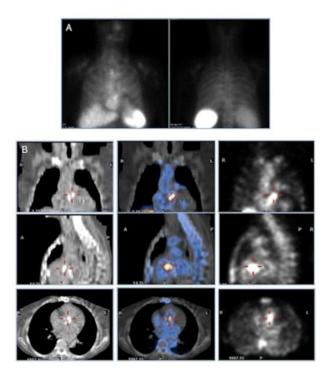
^{99m}Tc-HMPAO-WBC scintigraphy demonstrating the value of SPECT/CT for precisely localizing the site of infection. (A) Planar anterior and posterior views (anterior in left panel, posterior in right panel), where focal uptake of radiolabeled WBCs mimic sternal osteomyelitis. (B) Coronal, sagittal, and transaxial CT sections in left panels, fused SPECT/CT sections in middle panels and SPECT sections in right panels. The tomographic images correctly localize uptake of ^{99m}Tc-HMPAO-WBCs at the mitral valve prosthesis.
